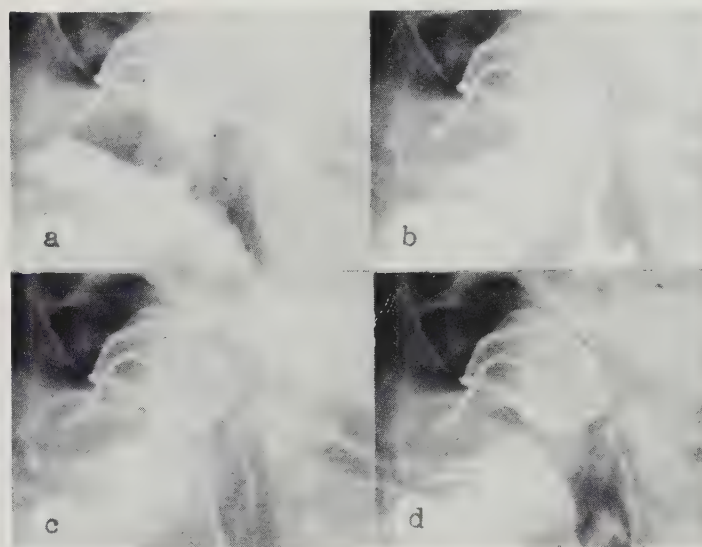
Séquences télé-radiographiques prises lors de l'ingestion d'un repas baryté montrant la progression de la crête de Passavant qui vient s'appuyer sur la partie postérieure de l'obturateur.
